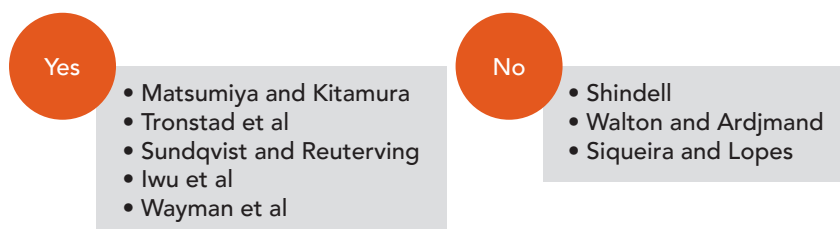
Authors who assert and deny the presence of live bacteria in periapical lesions.
